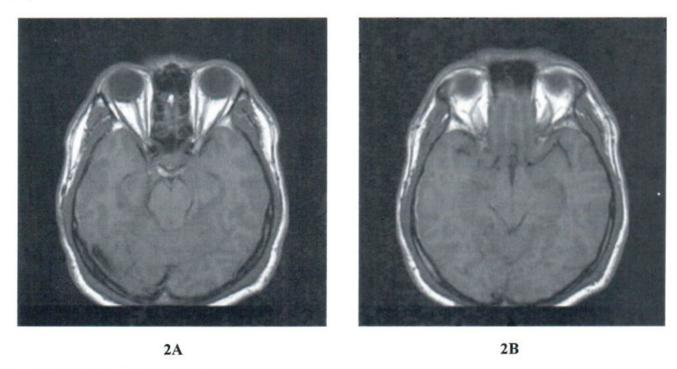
Axial SE T1-weighted images at the level of midbrain show elongated shape of the midbrain in AP dimension with effacement of basal cisterns due to descent of the midline structure.
